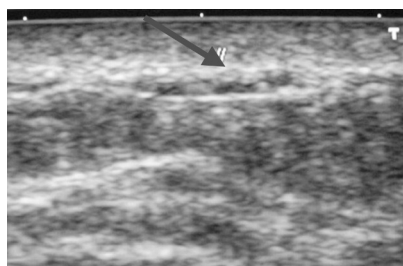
Ultrasound image showing the breast thrombophlebitis (arrow).
